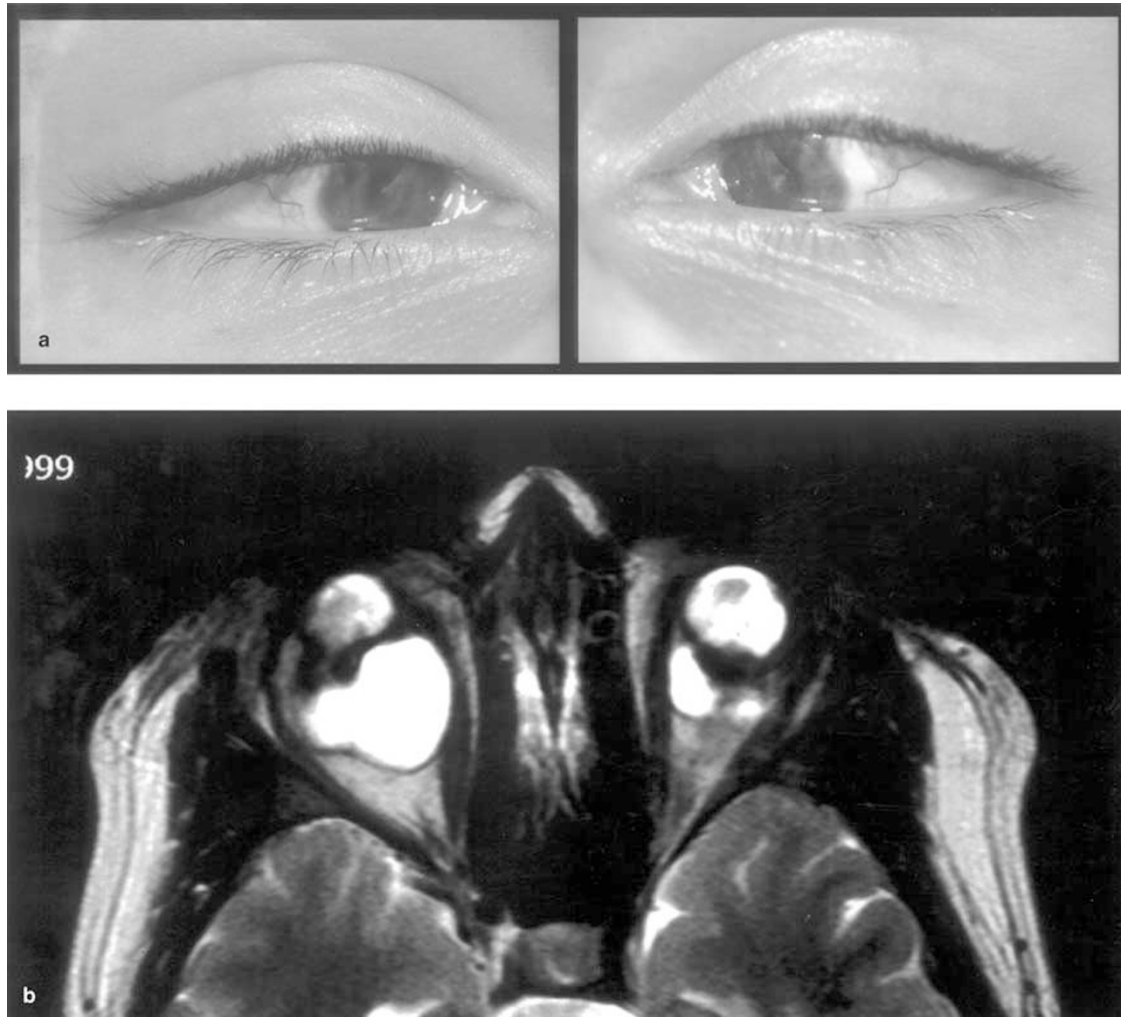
(a) External photograph shows bilateral microphthalmic globes with bilateral esotropia. (b) Magnetic resonance imaging displays bilateral microphthalmos with orbital cyst that is hyperintense to vitreous on T2-weighted images.
